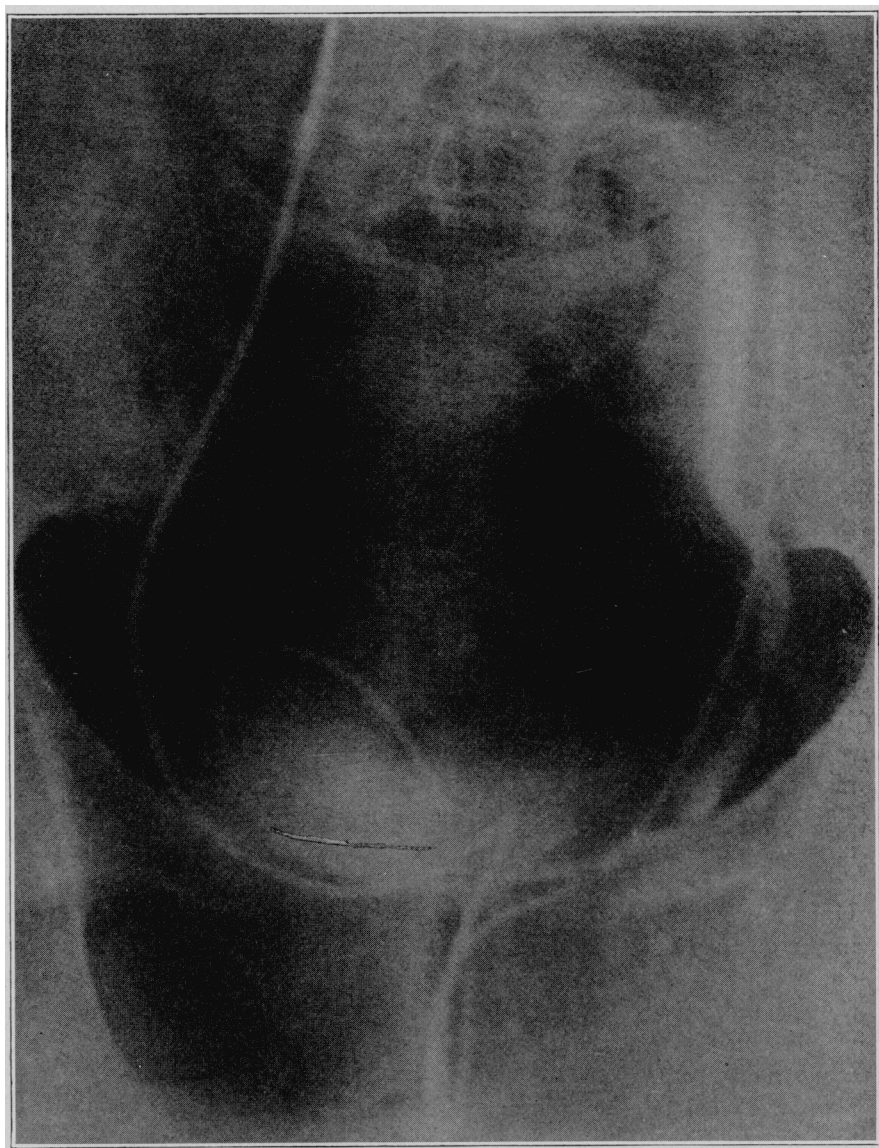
(Mrs. R.). Left lower ureterogram. Irregular shadows, shown near the bladder in the original roentgenogram, are localized by this ureterogram. The patient subsequently passed four small stones spontaneously. It will be noted that the upper pelvis of this kidney and its ureter were free from stones. A 17.5 per cent. sodium iodid solution was used.
